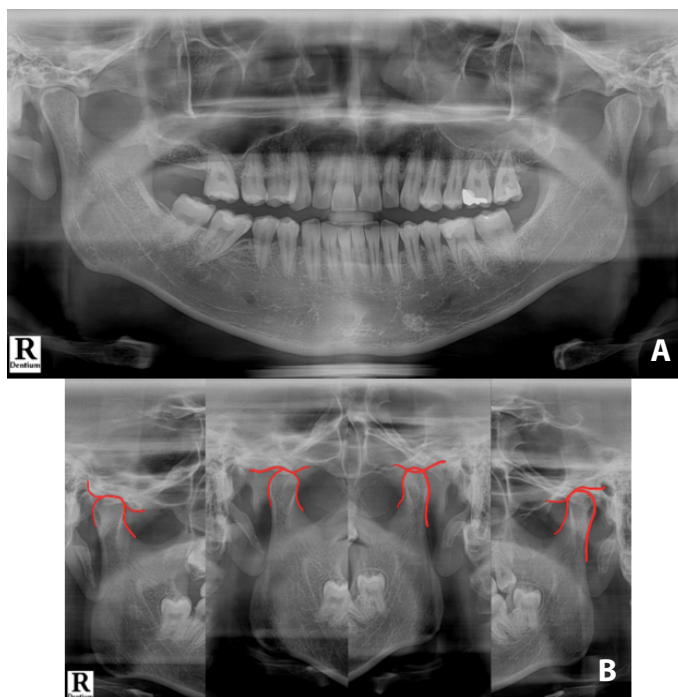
A. Panoramic radiograph, B. TMJ Radiograph
